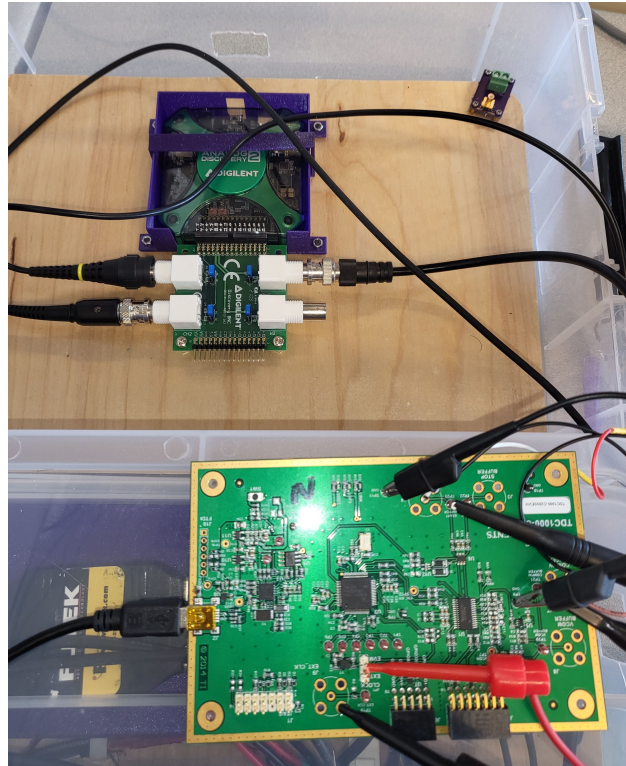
Ultrasound data acquisition setup. TDC1000-C2000 EVM (on the bottom of the Figure) hooked up with probes to the Analog Discovery 2.0 portable oscilloscope (on the top of the Figure).
